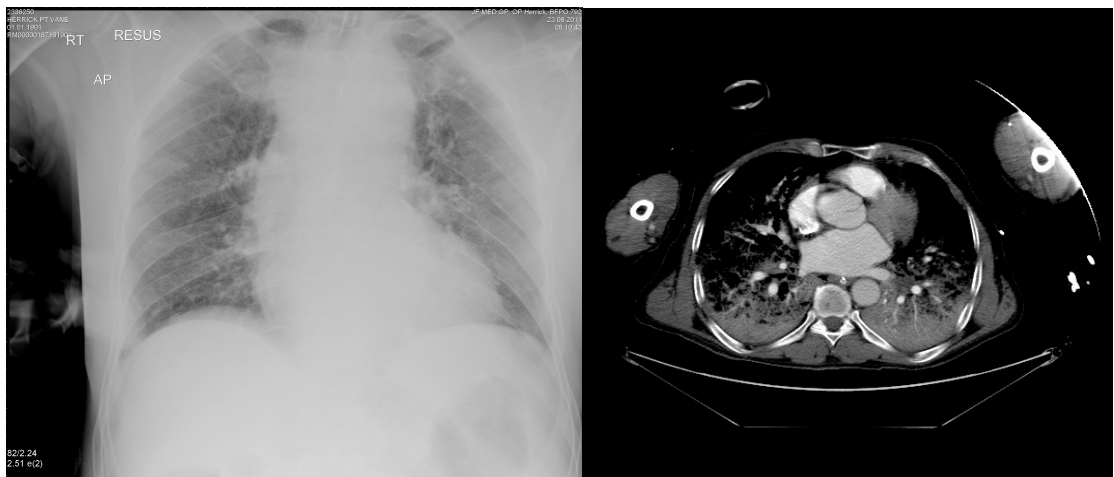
CXR and CT demonstrating severe blast lung injury. This Afghan local national was the victim of an improvised explosive device, and sustained a combination of severe primary and secondary blast injuries. His CT scan shows evidence of severe blast lung injury.
